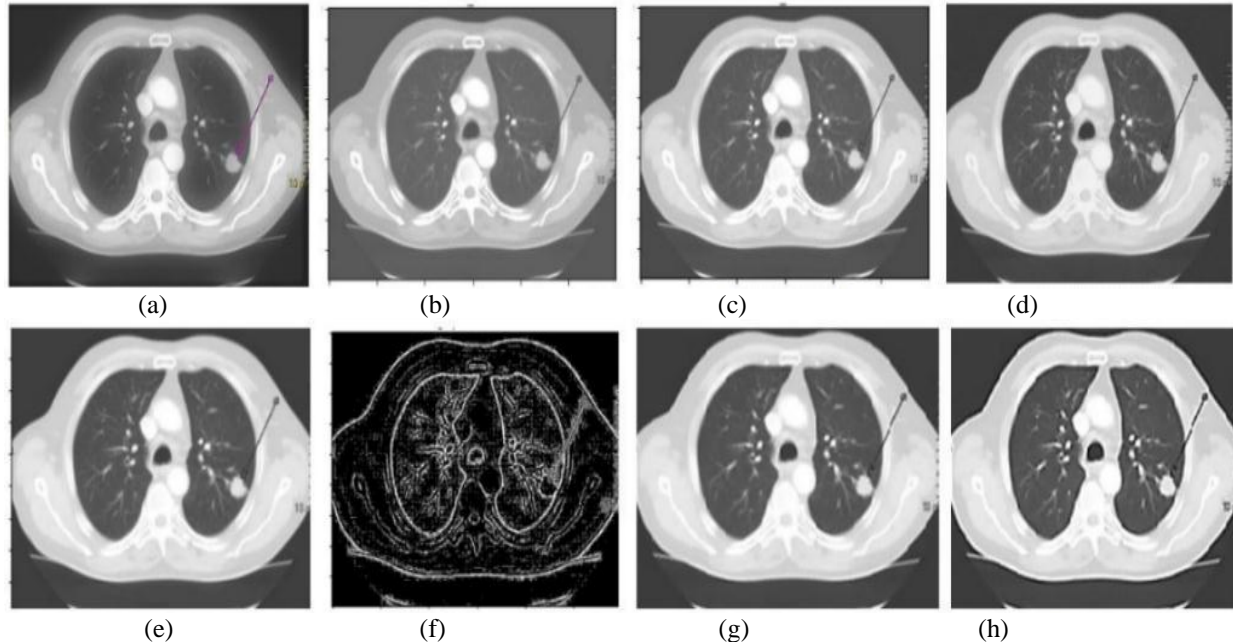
Qualitative Aspect of various denoising filters on a Lung adenocarcinoma 2D-CT scan (a) Original image (b) Mean filter (c) Median (d) Gaussian (e) Weiner (f) Fourier high pass (g) Wavelet (h) 2D-FrFT
